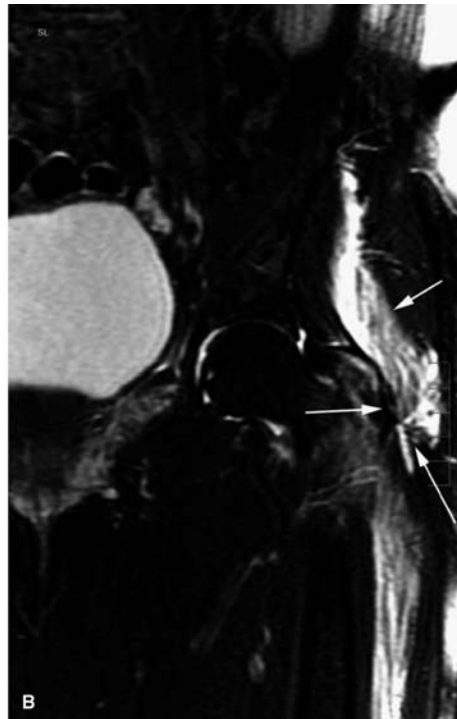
Greater trochanter fracture. This 68-year-old female sustained a greater trochanter fracture, difficult to appreciate with plain radiography (A). The subsequent coronal T2-weighted MRI (B) shows the edema in the greater trochanter and adjacent hip abductors (*arrows*). MRI is useful in the differentiation of surgical and nonsurgical management.
